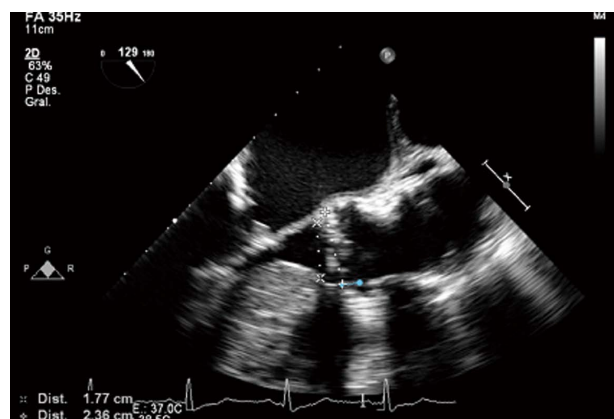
Transesophageal echocardiography 2D at 129° in long axis view in systole with measurements of the left ventricular outflow tract and aortic annulus. The measurement in blue is the distance to the right coronary artery.
